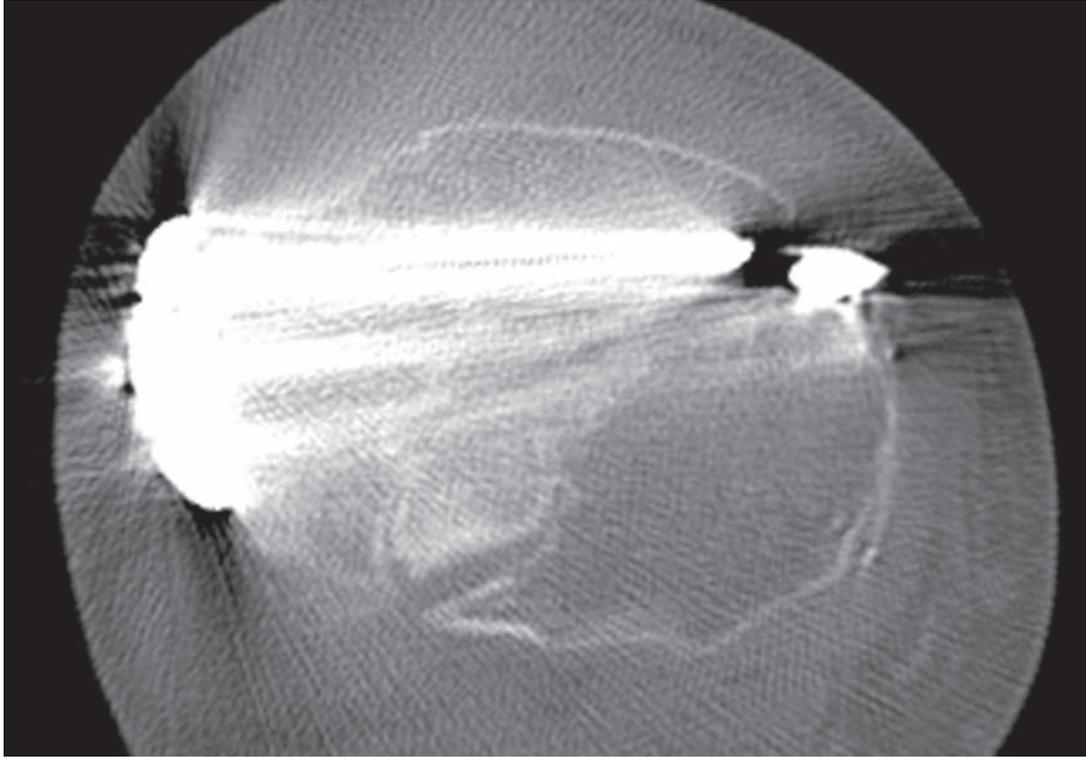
Axial CT image of a bicondylar tibial plateau fracture treated with a fixed-angle laterally applied implant. Note the suboptimal relationship of the locking screws to the relatively large posteromedial fragment.
